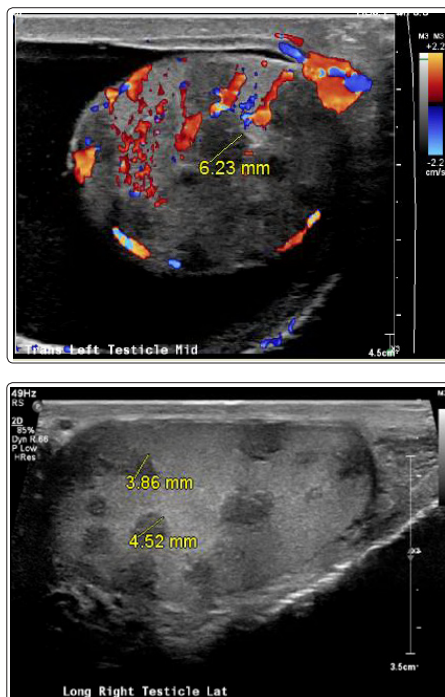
Testicular Ultrasound
